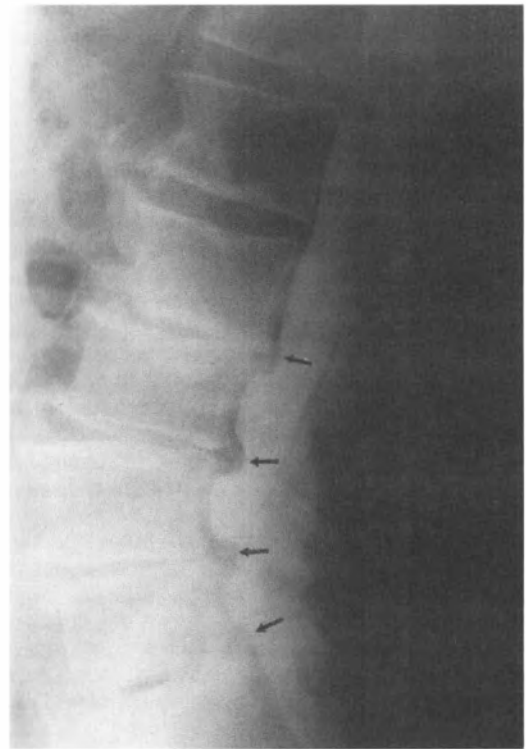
reveals an MRI sagittal image showing extensive degenerative changes at all lumbar disc levels and both anterior and posterior disc protrusions at the L2–L3 through L5–S1 levels. Myelography (Figs. 4.34 and 4.35) shows the decompressive laminectomy extending from L2 through L5 (*open arrows*). Massive osteophytes have ankylosed at the right L1–L2 level and left L2–L3 level. L2 is posterior on L3 with extensive end plate sclerosis and retrolisthesis instability of L2 on L3. The L5–S1 segment shows vacuum change, and all lumbar discs demonstrate extensive degenerative changes. The myelographic column shows an
